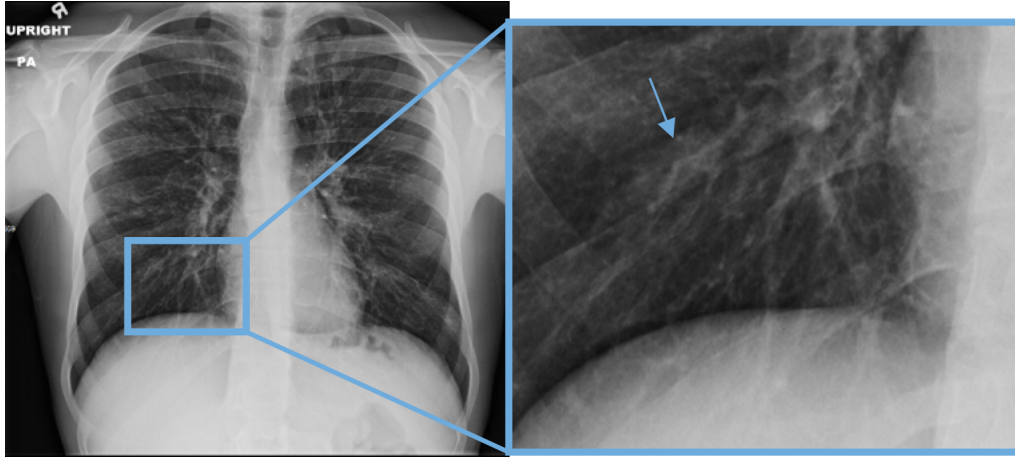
A clinical CXR upright PA chest radiograph. The magnified region shows some linear markings
